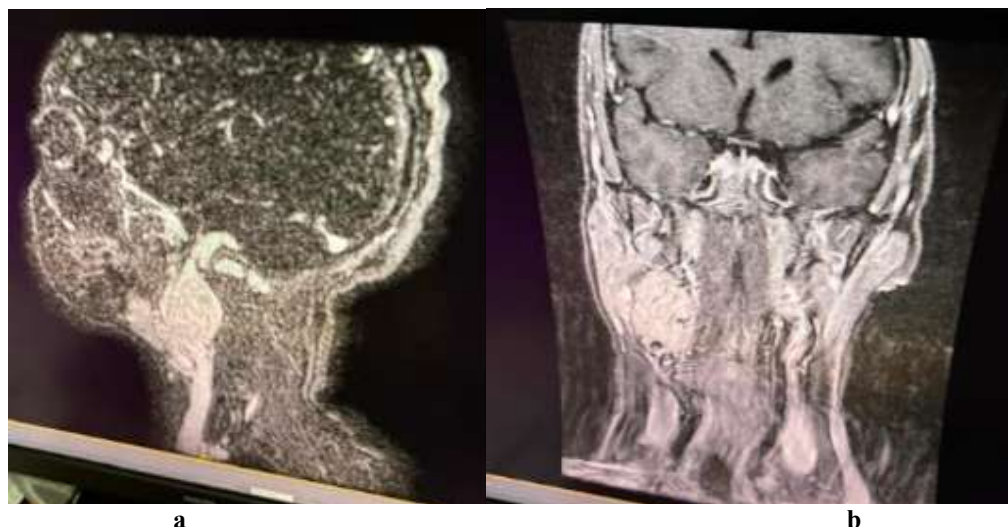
sagittal (a) and axial (b) cross-section from a CT angiography of the supra-aortic trunks showing the right carotid paraganglioma measuring 41x29x64 mm in diameter prior to radiotherapy
